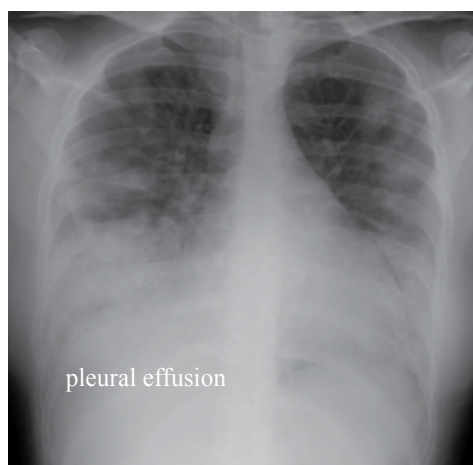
Chest radiography shows marked cardiac dilatation and pleural effusion.
